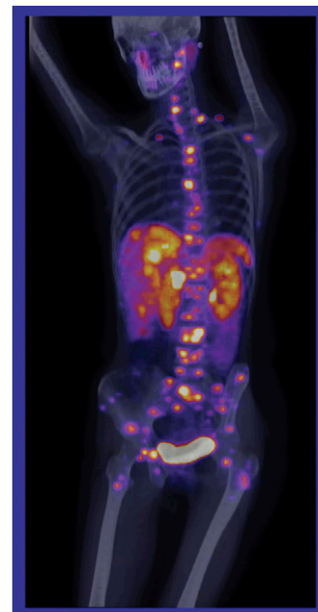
Whole-body PET/CT provides an opportunity to study the distribution of neuroendocrine tumors and to monitor a growing range of therapeutic approaches.
